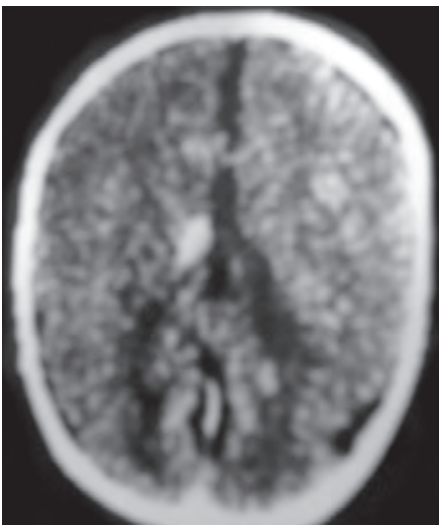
CT scan showing slit ventricles following ventriculoperitoneal shunt
